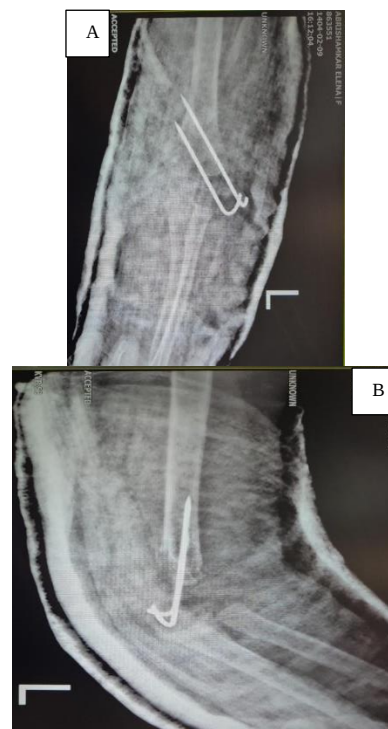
Anteroposterior (AP) (A) and lateral (B) radiographs of the elbow obtained postoperatively
